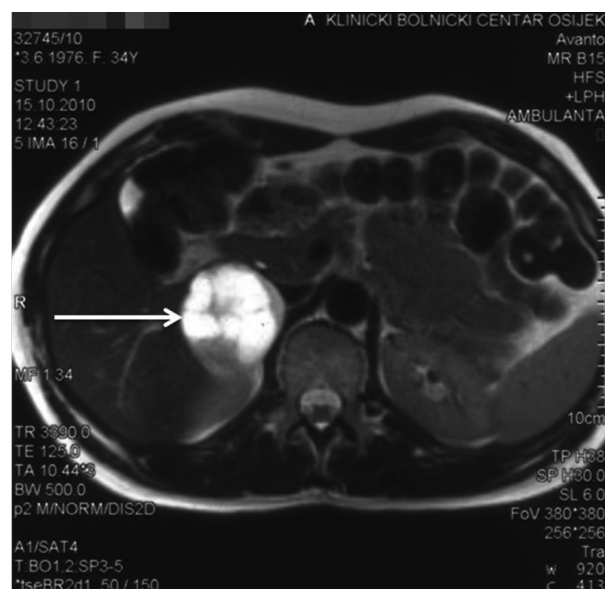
MRI of the abdomen, showing an oval, mostly hyperintense and only marginally hypointense zone in the suprarenal area.
